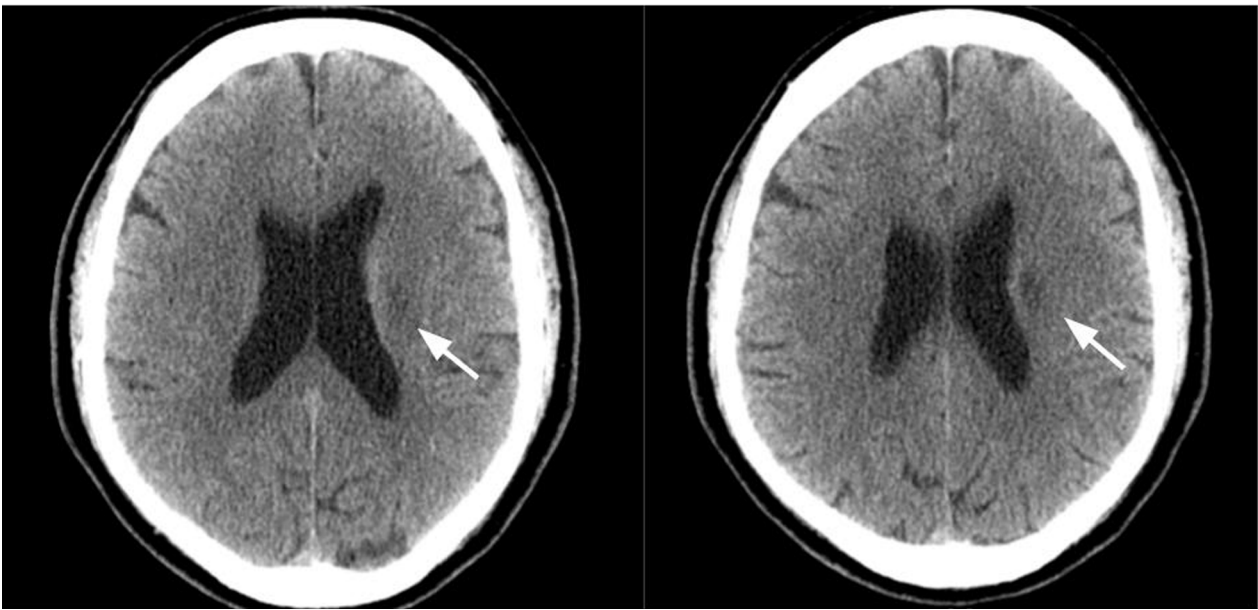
Brain CT showed left corona radiata hypodense lesion.
